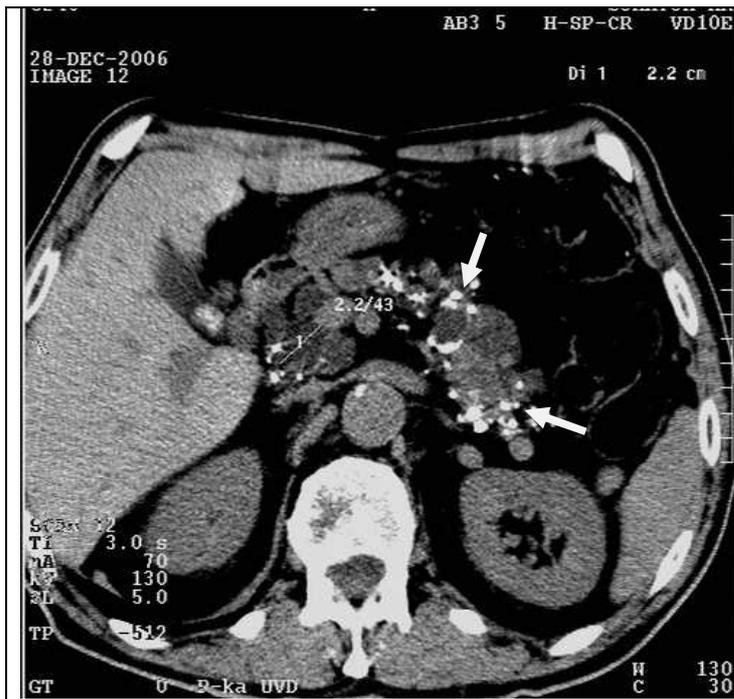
CT improves morphology lesions, especially one of the most important signs - calcifications in pancreas (arrows). Chronic pancreatitis
